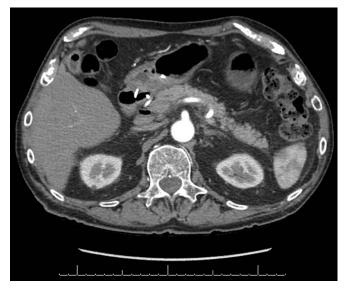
Computed tomography at 12 week follow-up demonstrates catheter between gastric antrum and collapsed cystic cavity posterior to the antrum of stomach, with resolution of air and fluid collections seen previously.
